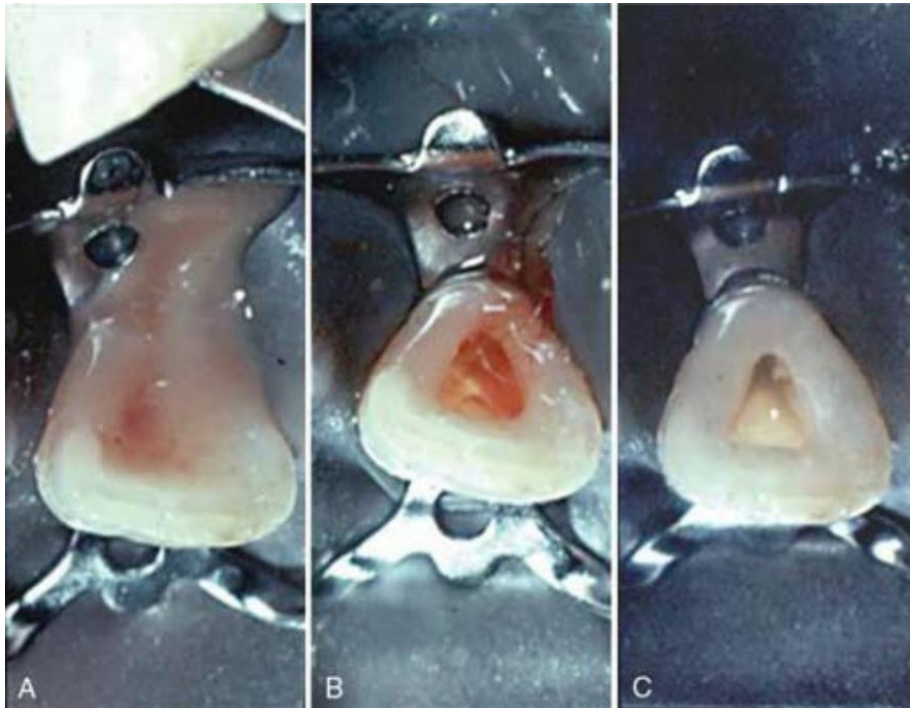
Nonvital infected tooth with active drainage from the Periapical area through the canal. A, Access opened and draining for 1 Minute. B, Drainage after 2 minutes. C, Canal space dried after 3 Minutes (Pathways of the pulp 12th edition)
